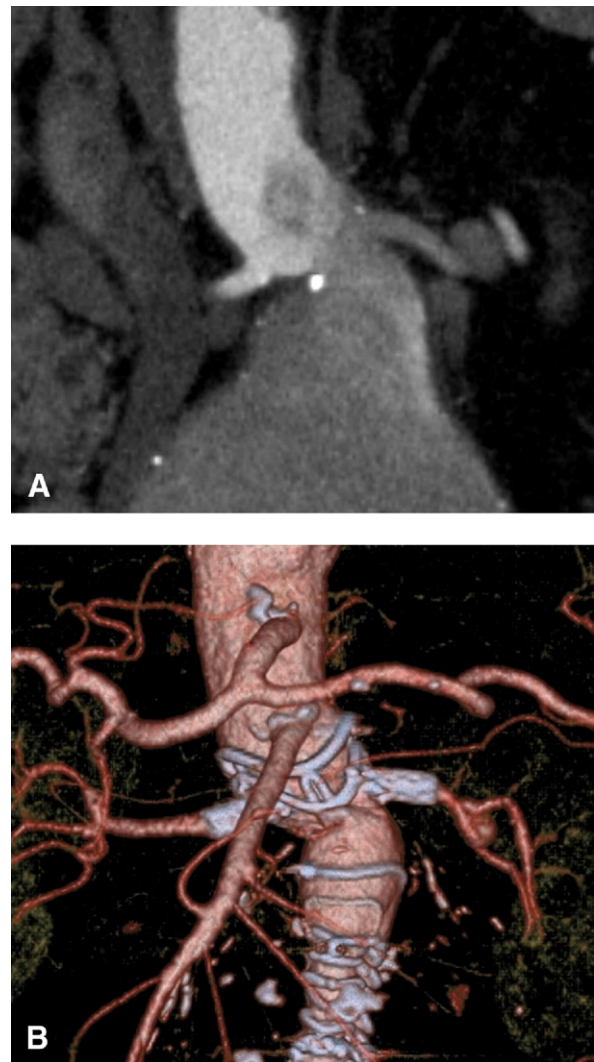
A, A computed tomography angiography (CTA) reconstruction of the 74-mm juxtarenal abdominal aortic aneurysm is shown for patient 1. A web-like stenosis of the left renal artery is clearly seen. B, A volume-rendered reconstruction of the 6-month follow-up CTA shows the fenestrated graft has excluded the aneurysm.
